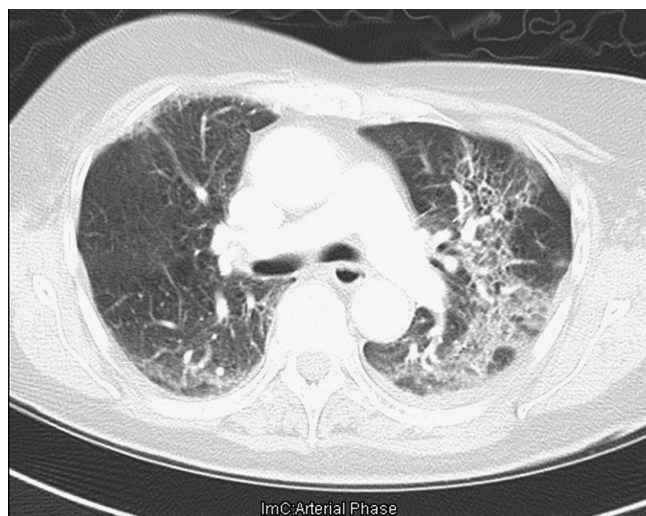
CT of chest demonstrating extensive interstitial changes in the left lung.
